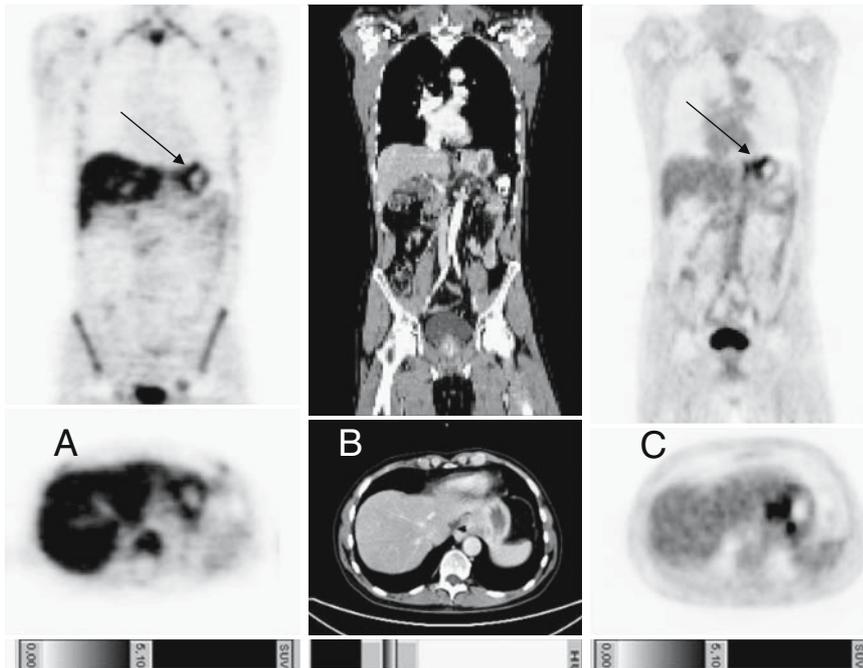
Visualization of locally advanced gastric cancer (*arrows* in A and C) with A FLT-PET, B computed tomography (CT), and C FDG-PET. FLT, fluorothymidine
